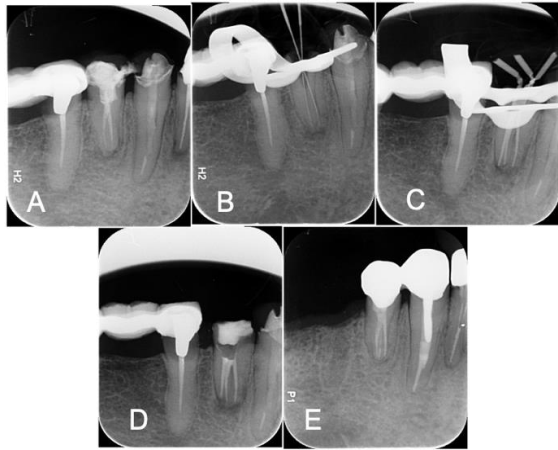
#34: (A) Preoperative periapical radiograph; (B) periapical radiograph with old GP removed and working length determined; (C) periapical radiograph with master cones; (D) periapical radiograph showing final obturation; (E) periapical radiograph after 6 months follow-up.
